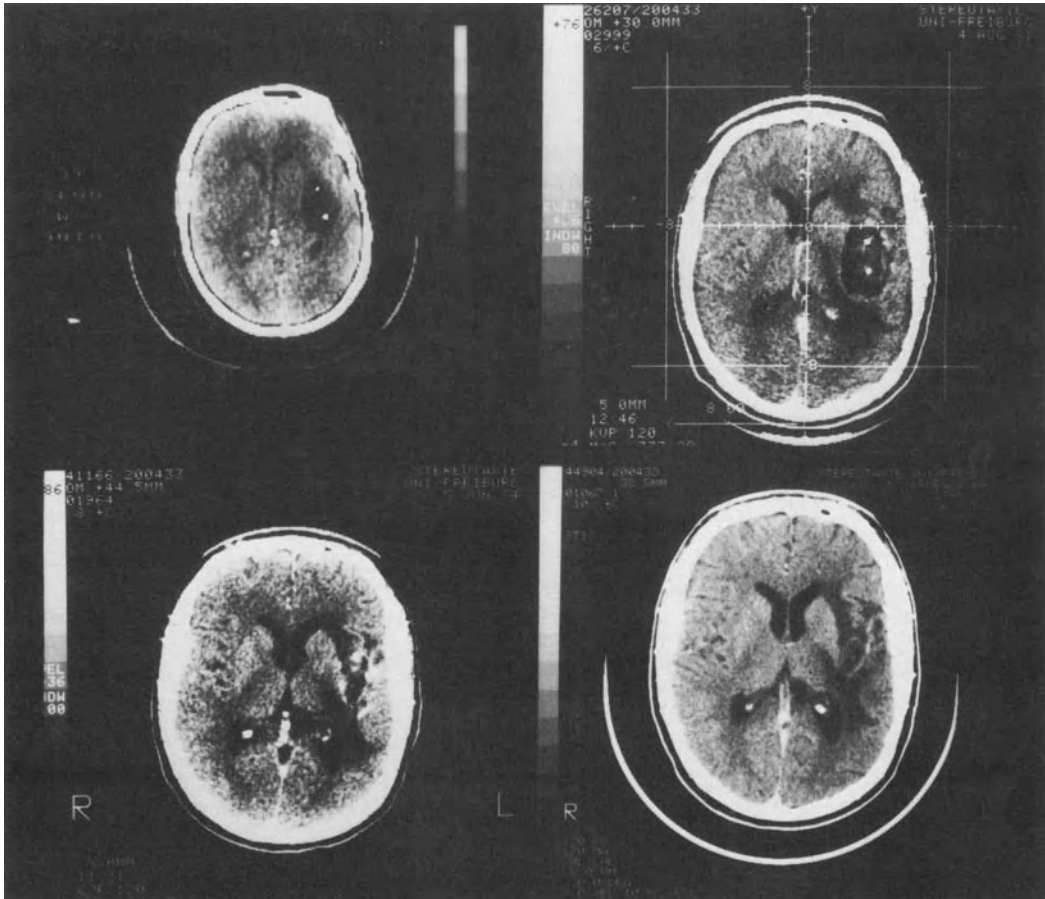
Stereotactic CT-confirmed grade II fibrillary astrocytoma in a 32-year-old patient. Clinical course following ^{125}I Curietherapy:
